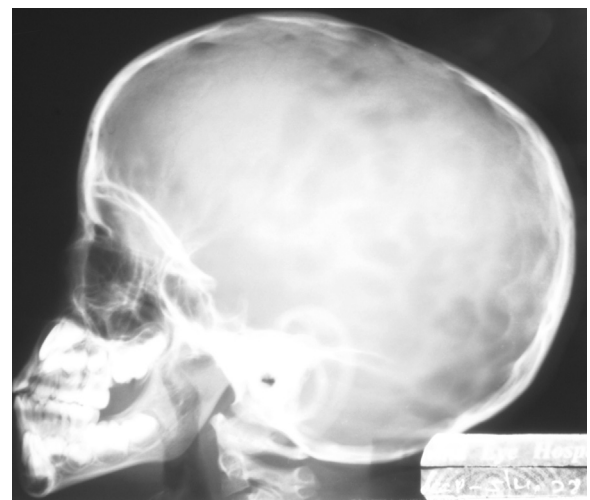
A, Skull X-ray showing multiple focal areas of radiolucency in the skull bounded by dense bony ridges.
